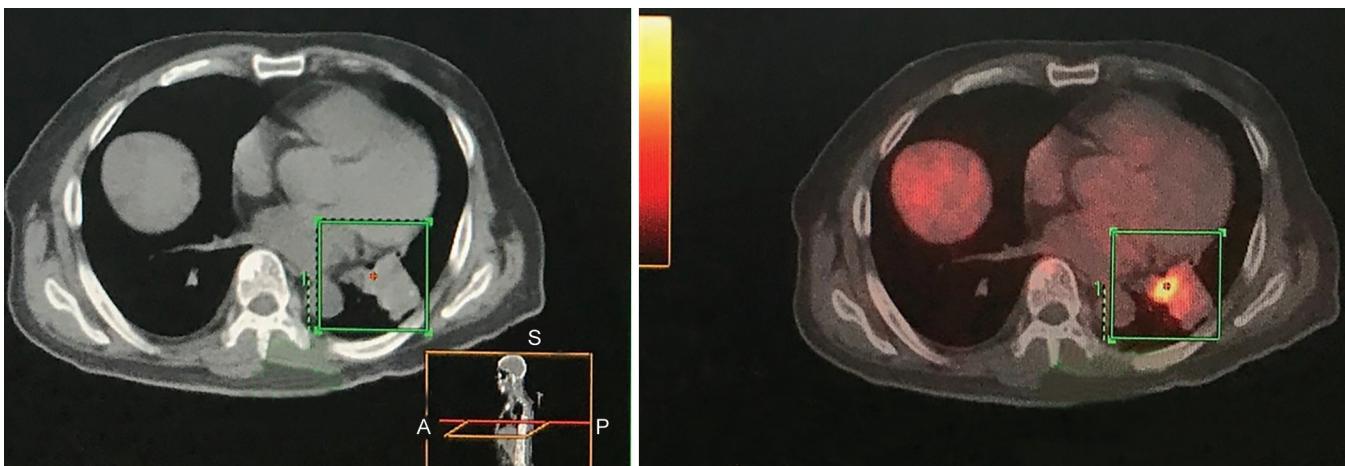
CT/PET Ga-68 showing an irregular mass at the left lower lobe of the lung with Ga-68 DOTANOC uptake
